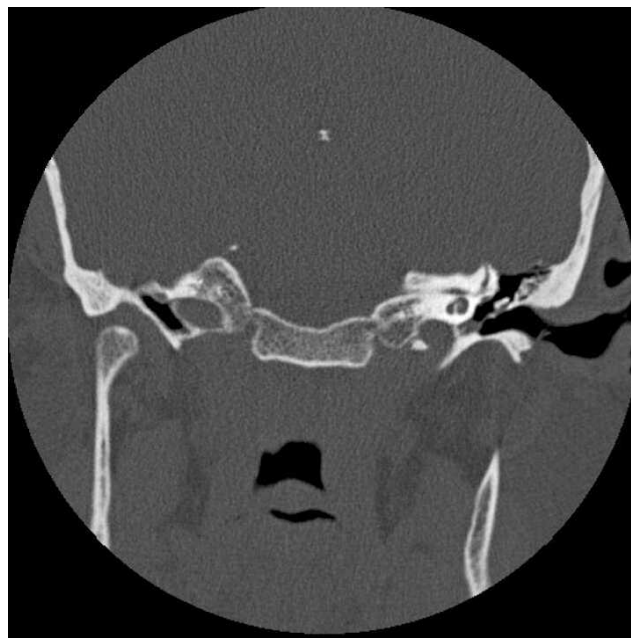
High-resolution computed tomography image of a patient with superior semicircular canal dehiscence syndrome.
